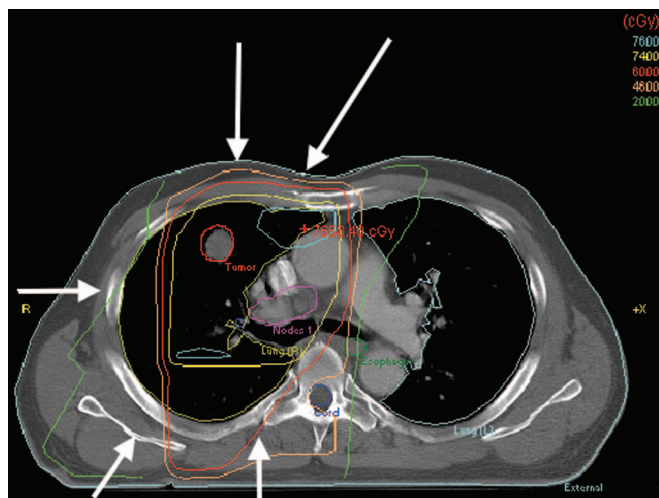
Dosimetry from a plan for a patient treated on NCCTG trial N0028. Tumor and adenopathy are encompassed within 74 Gy isodose (yellow). The five beams were composed of 6-MV x-rays directed in the direction of the five arrows. The isodose lines shown include the following: 76 Gy (blue), 74 Gy (yellow), 60 Gy (red), 46 Gy (beige), and 20 Gy (green).
